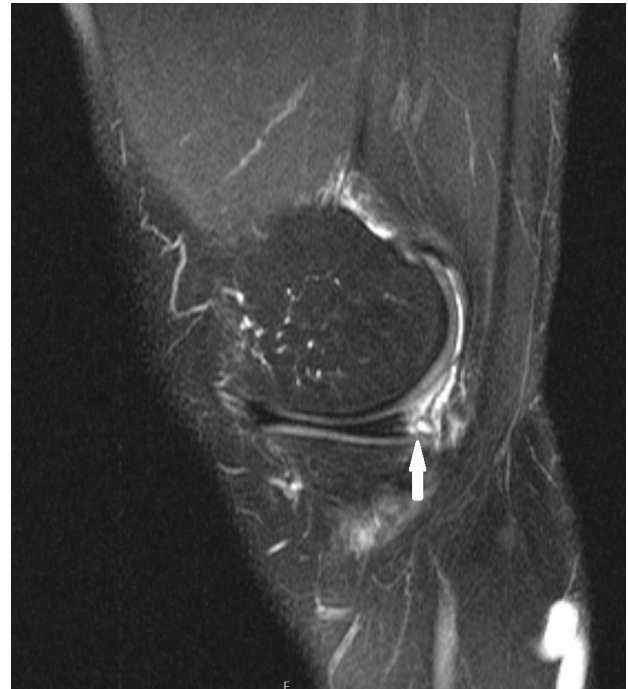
A T2* Fat Suppression MRI sequence showing structural heterogeneity of the posterior horn of the internal meniscus, with a longitudinal fracture at this level, intercepting the inferior articular surface
